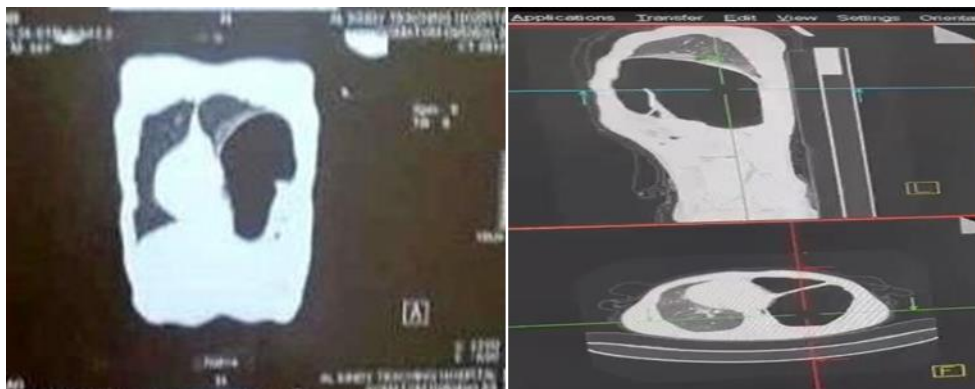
CT Scan of Chest Showing Gas Shadow in Left Side Compressing Lung Parenchyma and Displacing Mediastinum to Right Side
